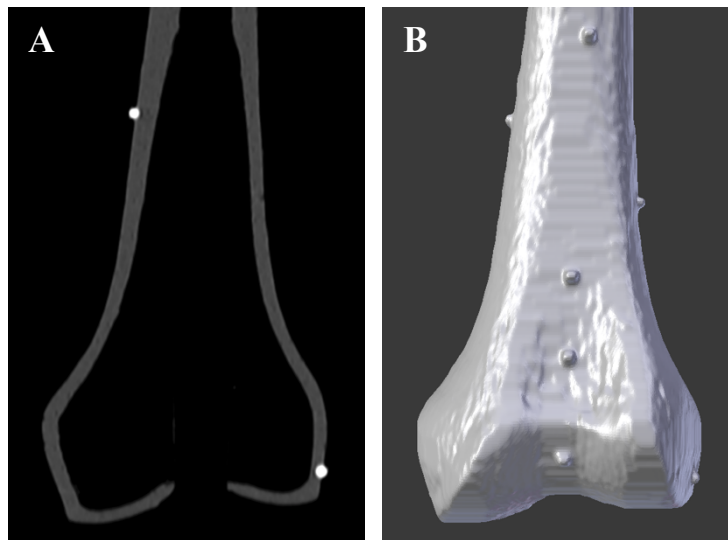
Sawbones femur model with distal portion prepped for fiducial bead placement and CT scan.
